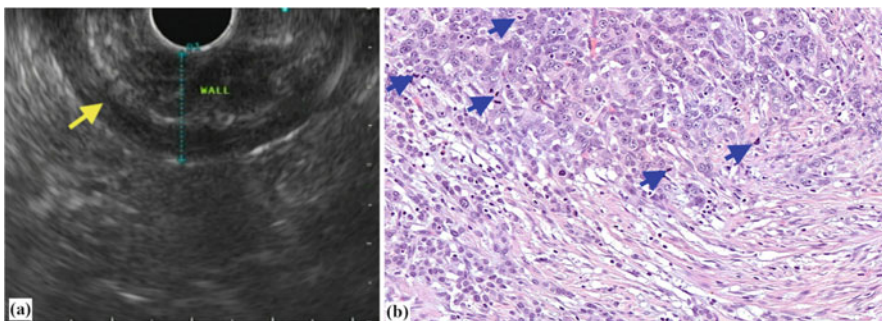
Advanced HDGC infiltrating the gastric wall: (a) endoscopic ultrasonography revealing diffuse thickening of the gastric wall (13.5 mm), particularly due to expansion of the mucosa and muscularis propria, and partial layer fusion (arrow); (b) the tumour displays poorly differentiated, pleomorphic poorly cohesive cancer cells with high mitotic activity (blue arrows) infiltrating the muscularis propria
